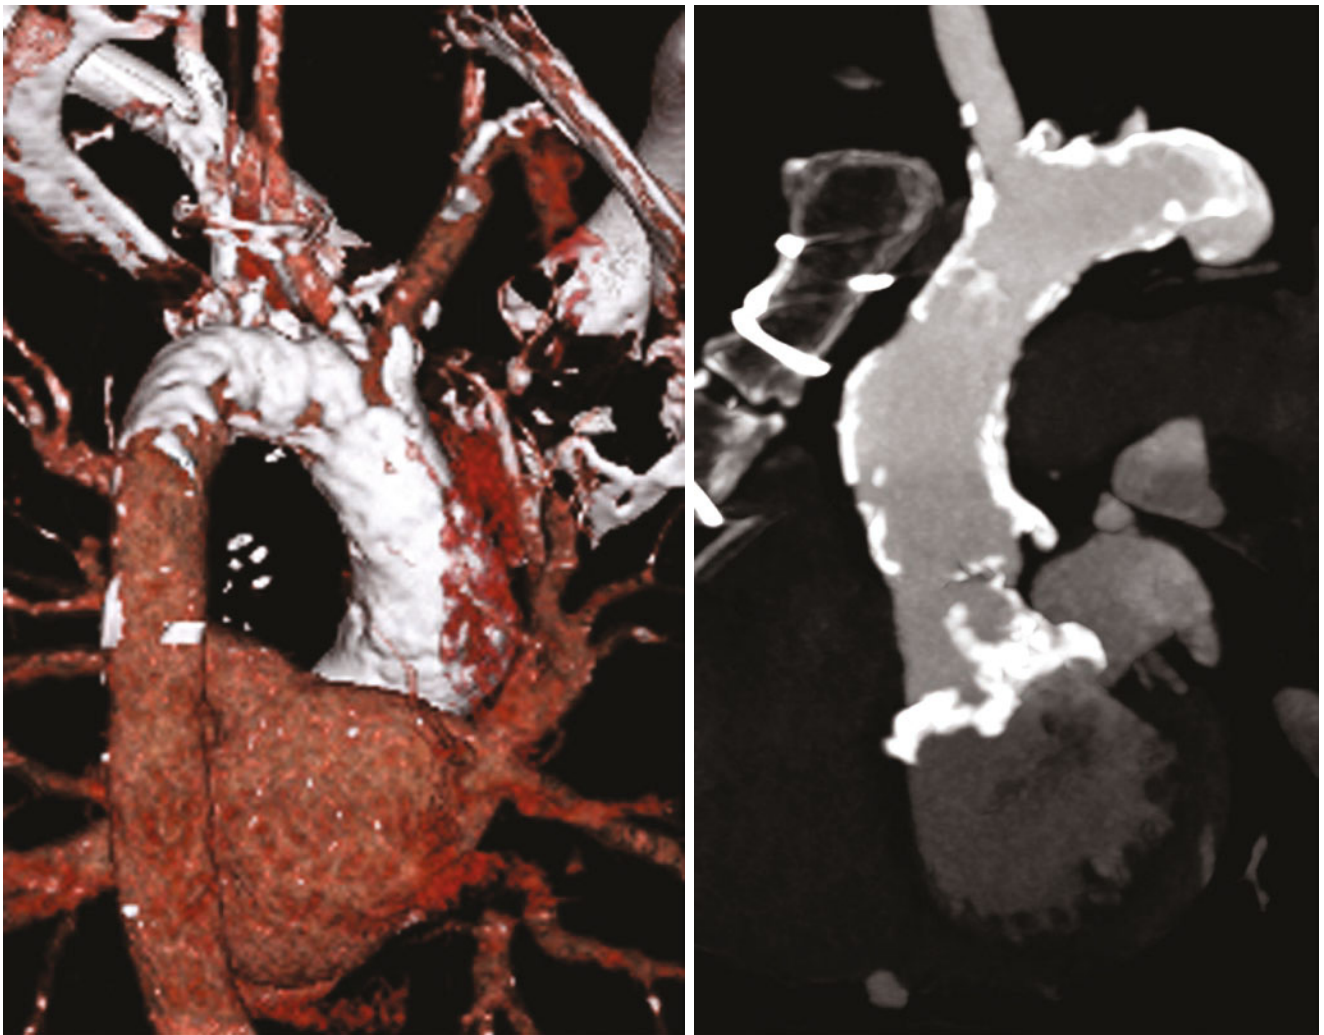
Coronary calcification. Particularly in postsurgical patients, atherosclerotic disease in the coronary arteries may be severe. (a–d). In this patient, extensively calcified disease in a nongrafted left circumflex coronary artery (CX) and large marginal branch (MO) makes accurate assessment of the lumen by CT virtually impossible. LM left main coronary artery
